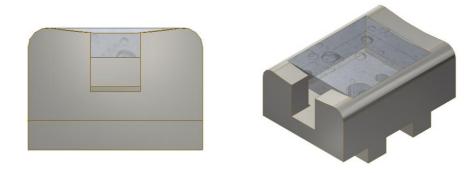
PLACEMENT OF ULTRASOUND GEL PAD IN TRANSDUCER HOUSING
